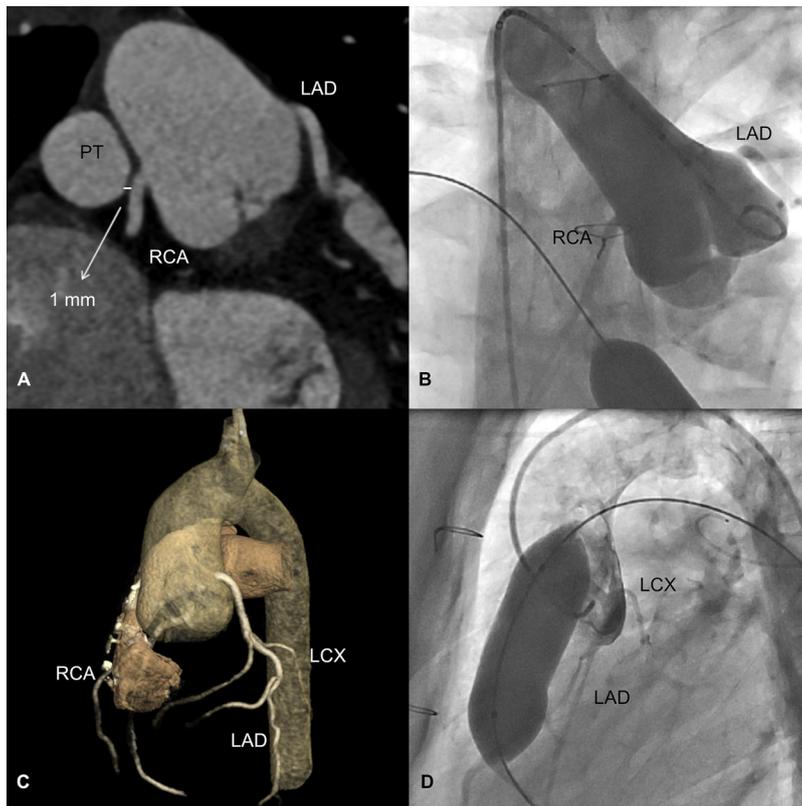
Patient with CC confirmed at balloon testing. Multiplanar reconstructed image (A) showing close relationship (1 mm) between right coronary artery (RCA) and pulmonary trunk (PT); RCA correctly fills with contrast before the balloon is inflated in pulmonary position (B). Volume Rendering showing calcified homograft (C). Selective coronary angiogram performed during balloon inflation (D): RCA is not visible because it doesn't fill with contrast, confirming compression. CT images are presented in the same projection of angiograms. LAD, left descending artery; LCX, left circumflex artery.
